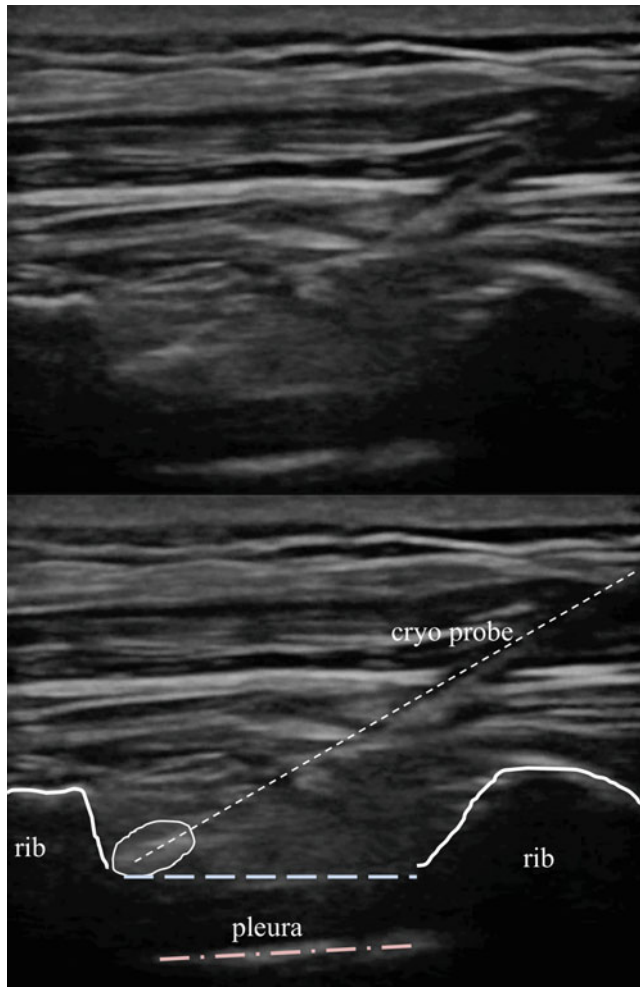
Cryoneuroablation probe placed under ultrasound direction (Image courtesy of Christ Declerck, MD)
